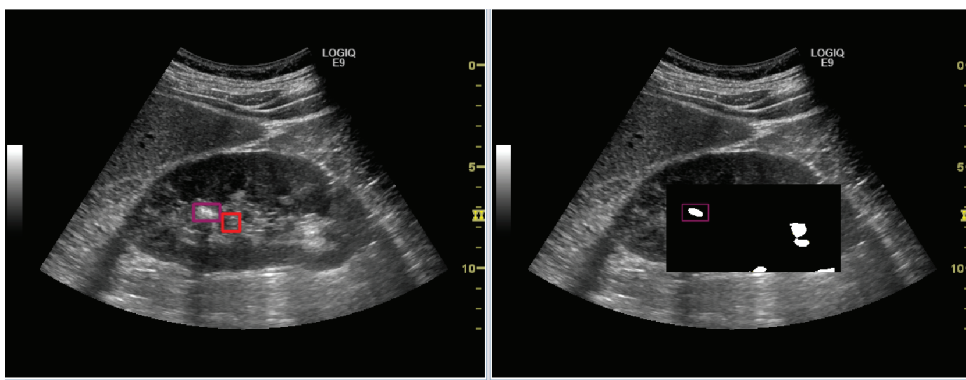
Kidney stone-tracking in ultrasound image, from [44]
